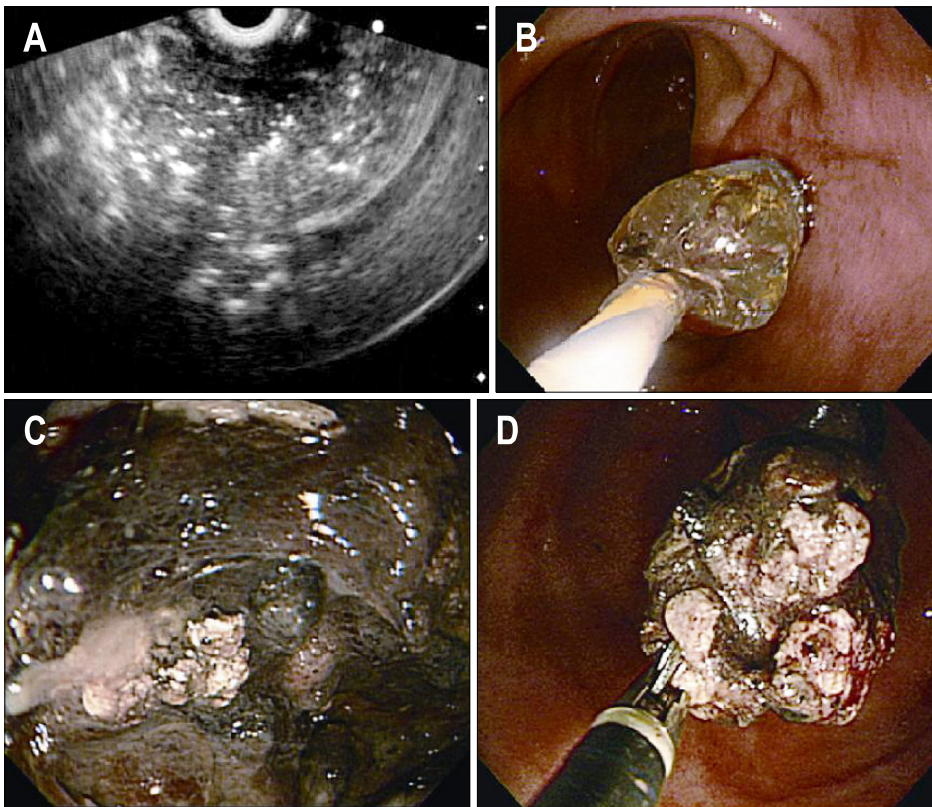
(A) Linear endoscopic ultrasound identified the pancreatic necrotic cavity with echogenic debris at the posterior wall of the low body. (B-D) After balloon dilatation, an endoscopic necrosectomy of the peritoneal area was performed. A large amount of necrotic materials and pus were removed.
